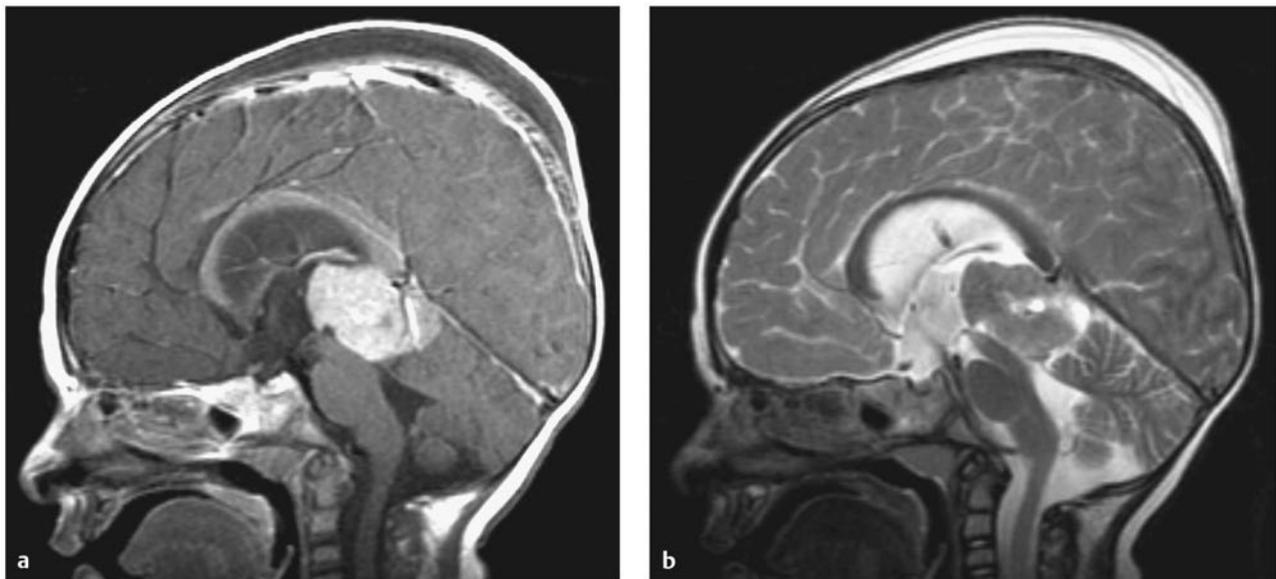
Trilateral retinoblastoma. (a) Sagittal T1-weighted magnetic resonance image with contrast and (b) the corresponding T2-weighted sequence of an 11-month old girl previously treated for congenital bilateral retinoblastoma. The images were obtained after an endoscopic third ventriculostomy and tumor biopsy (note the turbulent flow pattern at the site of the third ventriculostomy). This child with trilateral retinoblastoma underwent total resection of a pineoblastoma following induction chemotherapy.
